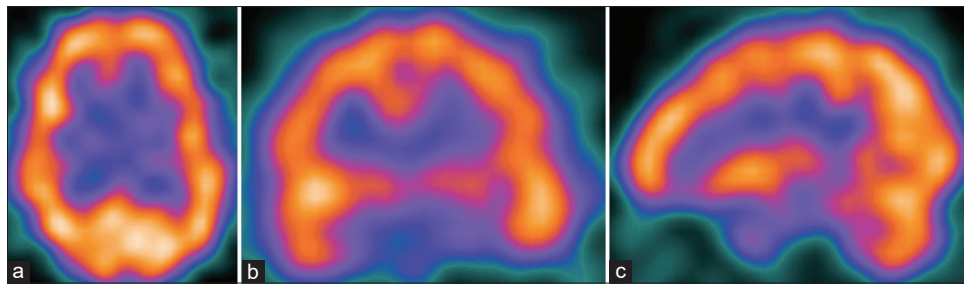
Preoperative single-photon emission computed tomography axial (a), coronal (b), and right side sagittal (c) slices of patient 1 showing hyperperfusion of the prefrontal areas, temporal lobes, right basal ganglia, and right parietal lobe.
